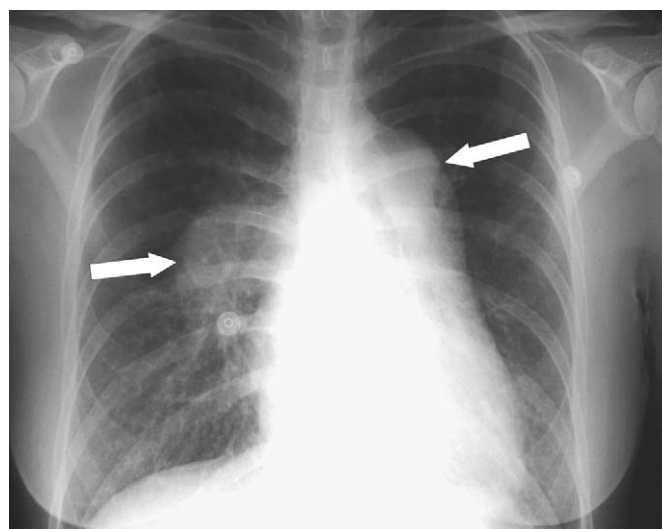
Chest x-ray of patient 1, with arrows indicating dilated pulmonary arteries.
